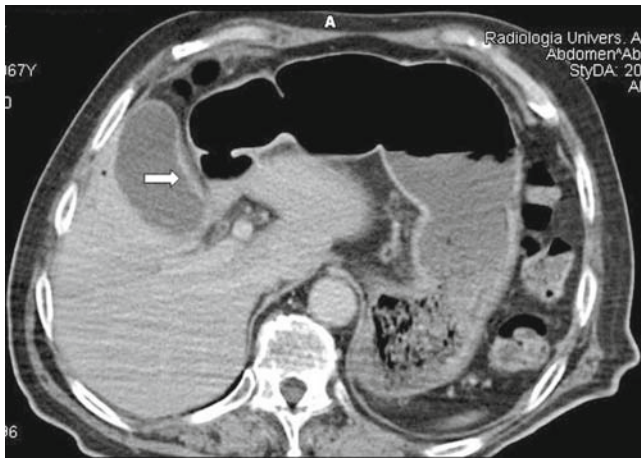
A computed tomography scan shows the distended gallbladder and perihepatic effusion. The *arrow* indicates the increased thickness of the wall of the gallbladder
